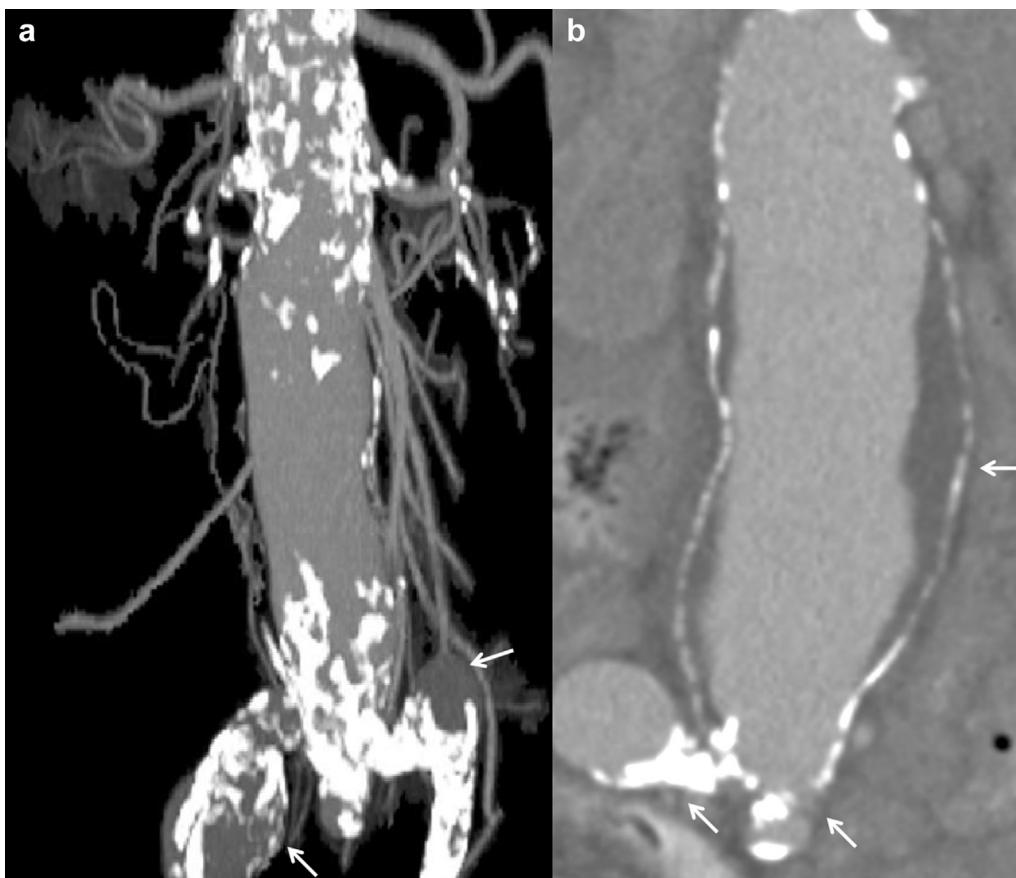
a, Computed tomography angiography three-dimensional reformatted image shows a heavily calcified, tortuous atherosclerotic aortoiliac system. Note the aneurysmal dilation of the bilateral common iliacs. b, Standard contrast-enhanced computed tomography coronal image shows extensive mural thrombus lining an infrarenal abdominal aortic aneurysm with tortuous origin of the common iliac arteries.
